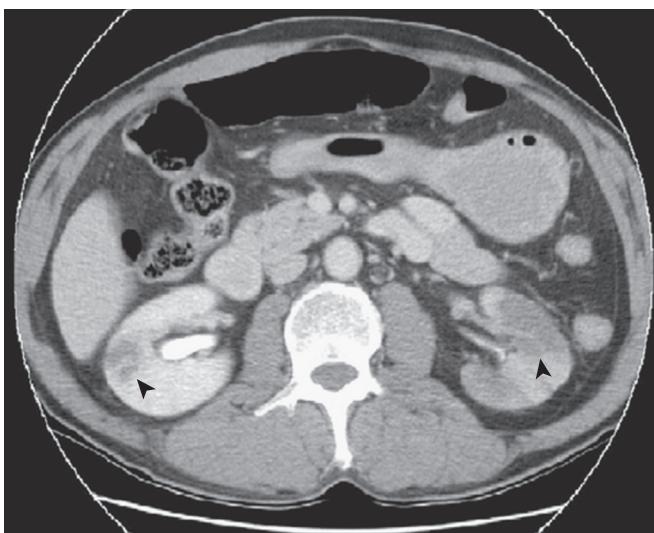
Computed Tomography Angiography Demonstrating Bilateral Renal Infarcts. Patient had sudden-onset bilateral flank pain with a history of atrial fibrillation. Bilateral wedge-shaped, hypodense lesions (arrowheads) are consistent with embolic renal infarcts. (From Huang C-C, Lo H-C, Huang H-H, et al. ED presentations of acute renal infarction. *Am J Emerg Med*. 2007;25(2):164–169.)
